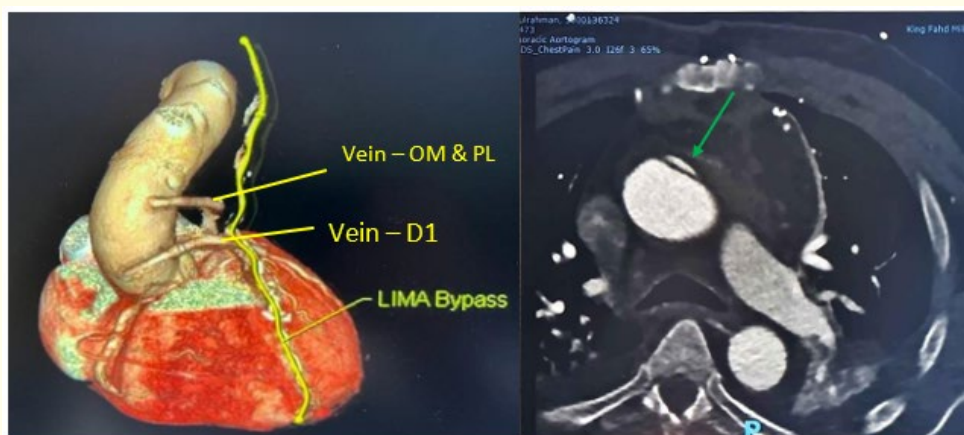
(A) 3D CT angiogram reconstruction showing the site of proximal anastomosis. (B) Follow up CT- scan findings Localized segment (Limited dissection about 3 cm) in the distal ascending aorta.
